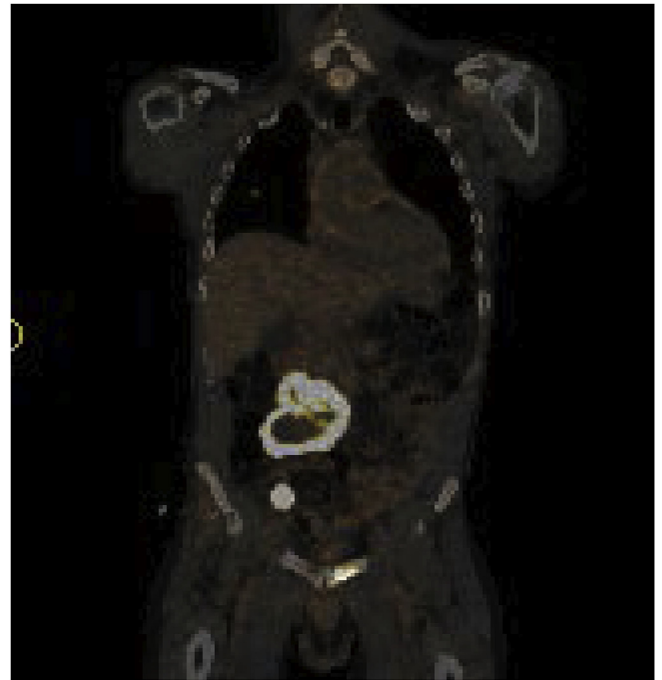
Post-operative coronal PET/CT scan demonstrating avid uptake in the right pelvic lymph nodes and right retroperitoneal mass.
